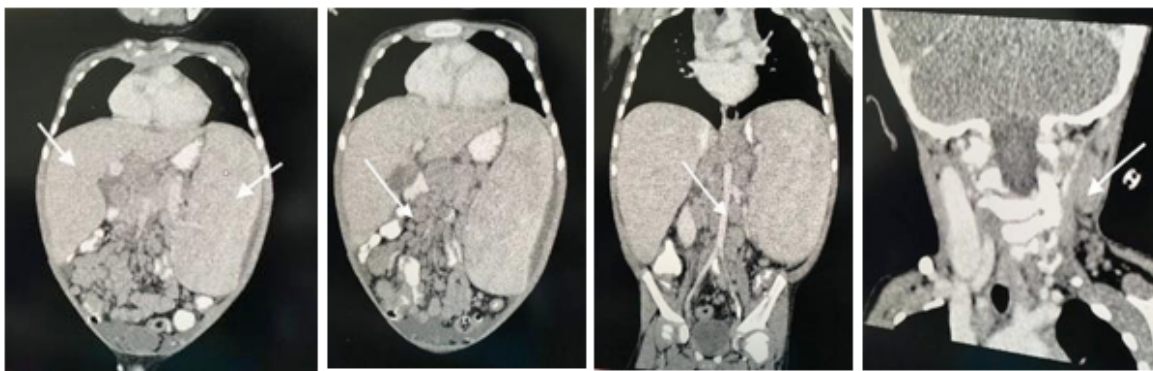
A. This is coronal cut showing a significantly enlarged liver and spleen. B. Abdominal CT showing multiple retroperitoneal lymph nodes. C. Abdominal CT and pelvis showing multiple mesenteric lymph node enlargement.
